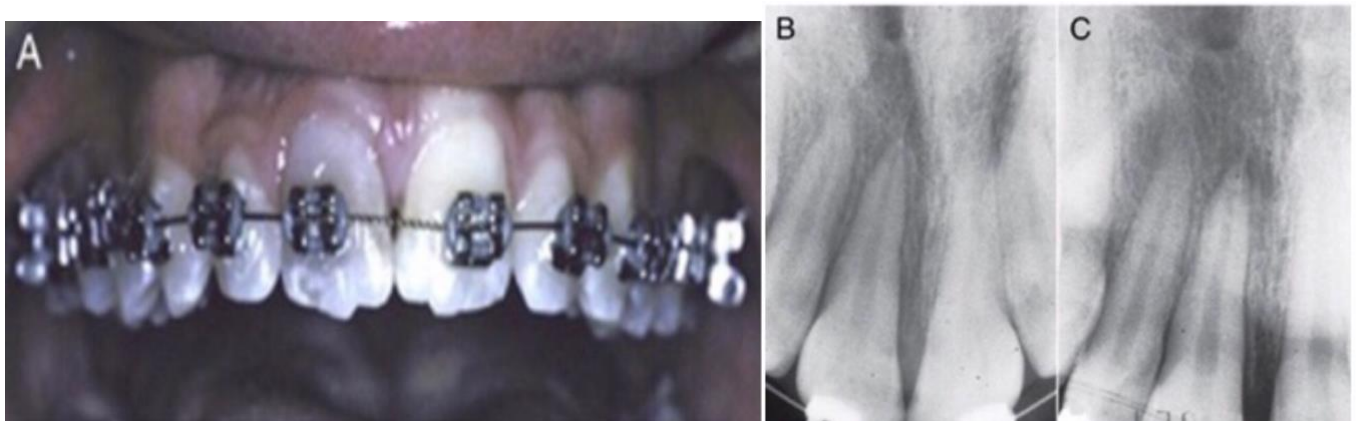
Patient experienced a concussion injury to the maxillary right central incisor while undergoing orthodontic treatment. (A) The archwire was changed to a lighter wire, the tooth was stabilized, and the radiograph revealed no pathology. Treatment progress continued within several weeks. (B and C) Follow-up radiographs revealed periapical pathology when exposed from multiple vertical angles. (Henry and John, 2013).
